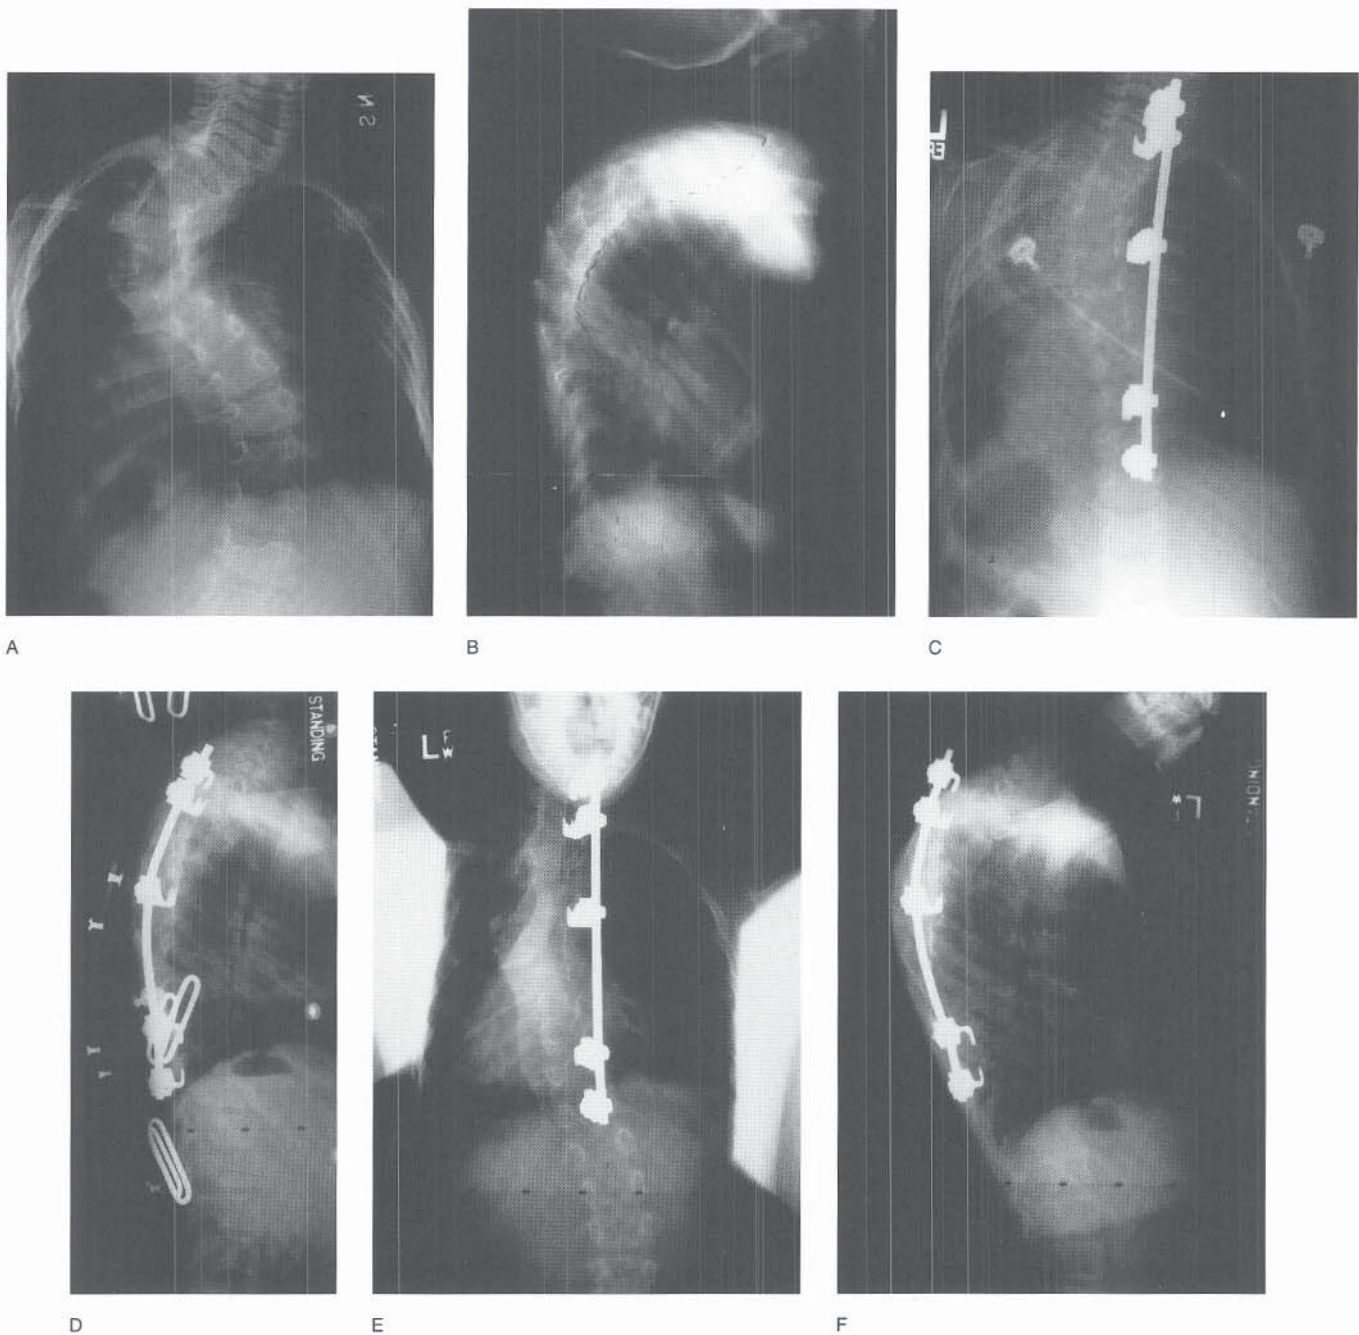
A and B, Radiographic appearance of a boy age 3 years 2 months with neurofibromatosis and severe upper thoracic kyphoscoliosis. C and D, A rib strut was placed anteriorly and a single rod was used posteriorly during fusion. E and F, Nearly 5 years later, frontal plane alignment remained satisfactory but the kyphosis was increasing above the instrumentation.
